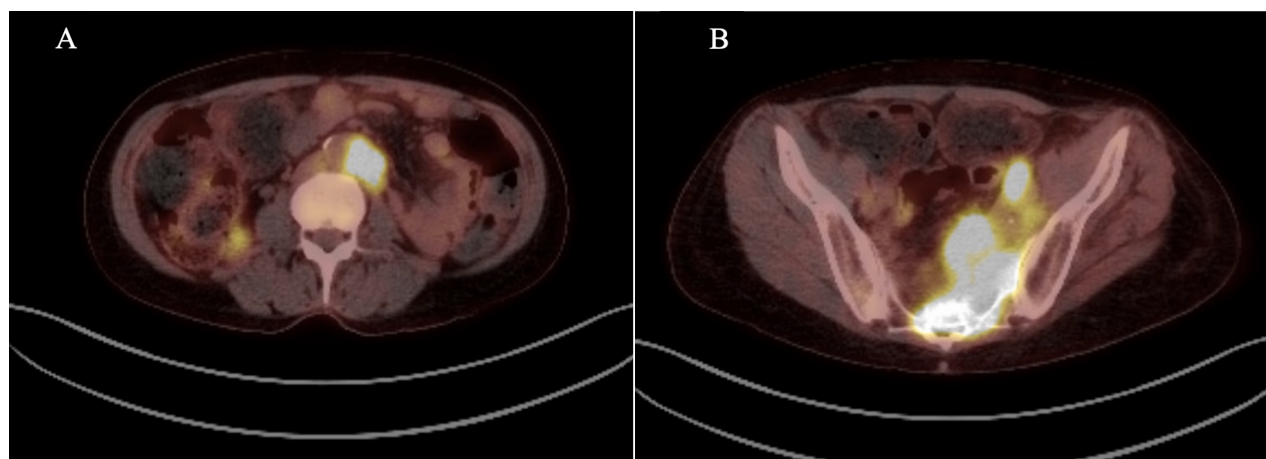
Initial Positron-Emission-Tomography (PET) scan showing fluorodeoxyglucose avidity. (A) Clear FDG avidity at the level of the para-aortic lymph nodes. (B) FDG avidity in the left-hemi pelvis correlating to pelvic mass as well as pelvic lymph nodes seen on CT and MRI scans.
